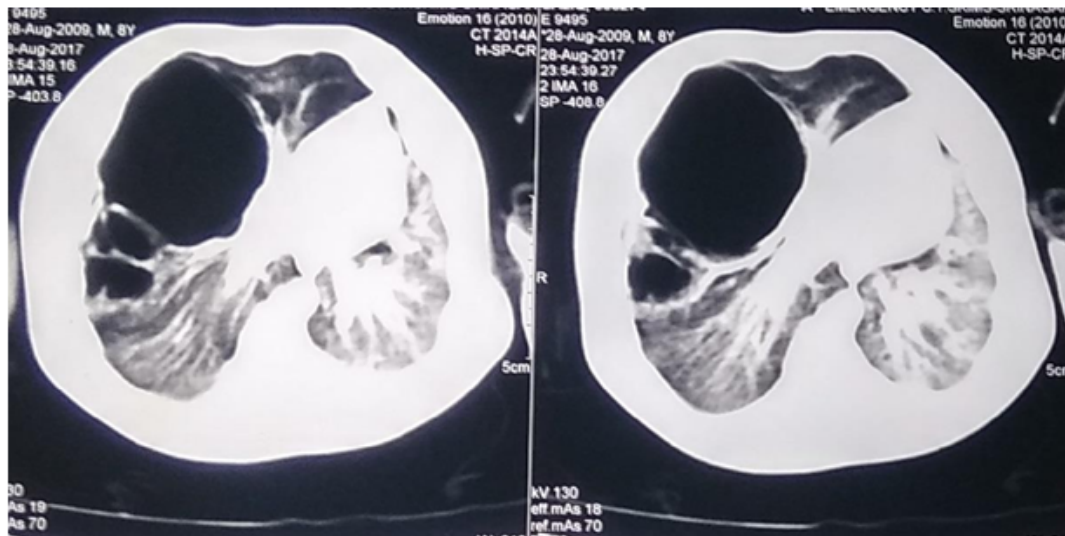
CT chest showing large cyst in right upper lobe CPAM
